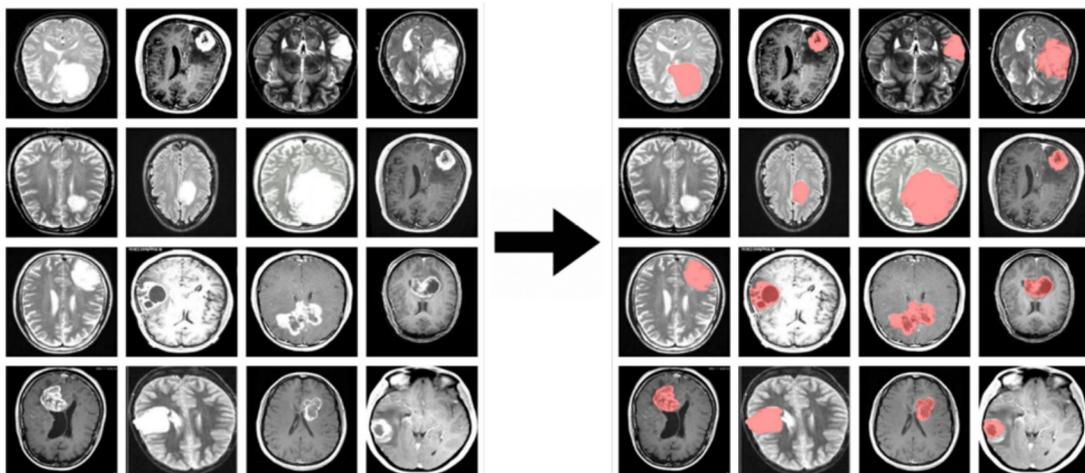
Detection of Tumors in Brain MRI Scans using the YOLOv8 Model.
